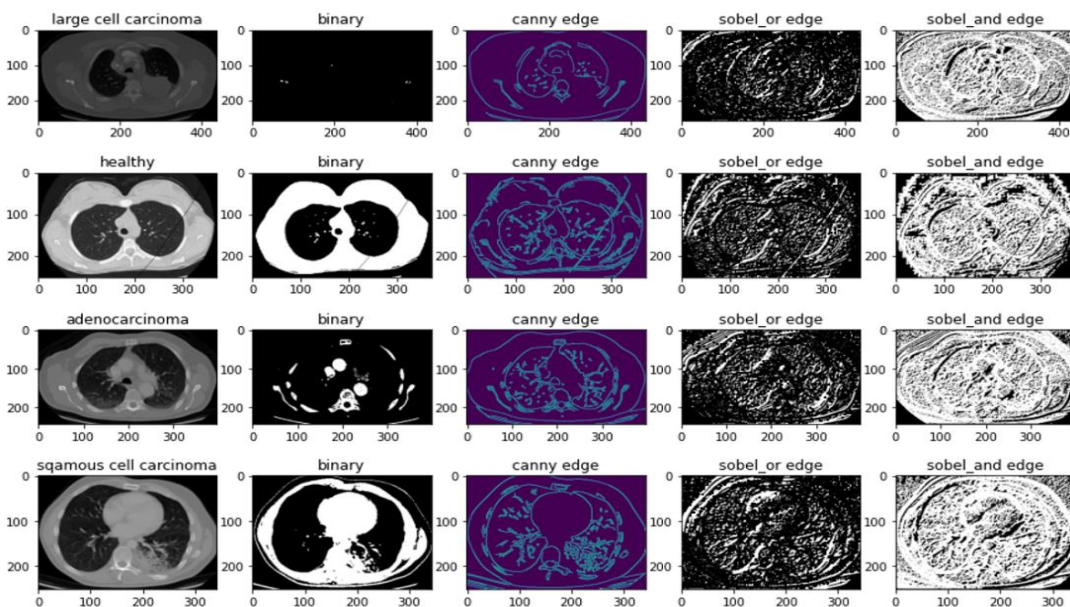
Binarized image, Canny edge detection and Sobel edge detection on chest CT-scan images
